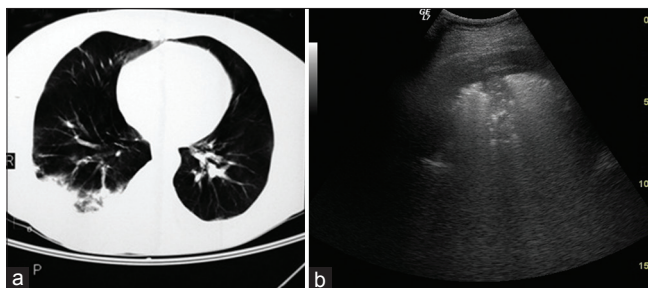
(a and b) Parenchymal window of thoracic computed tomography and sonographic examinations of pulmonary embolism case. Pleural-based, irregular-circumscribed, hypoechoic lesion with local pleural effusion at sonographic examination
